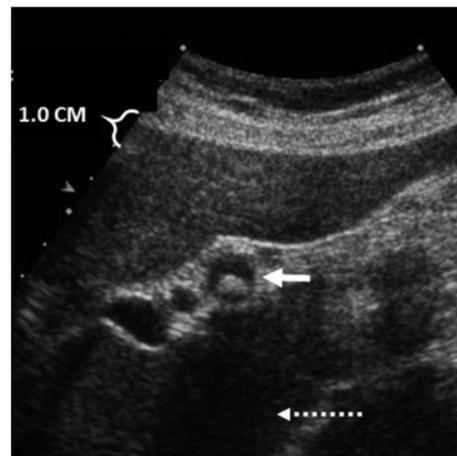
Transabdominal ultrasound of a patient who had a cholecystectomy nearly four years before developing recurrent biliary colic. A small remnant gallbladder with a retained or reformed stone was identified (solid arrow) with acoustic shadow (dashed arrow).
